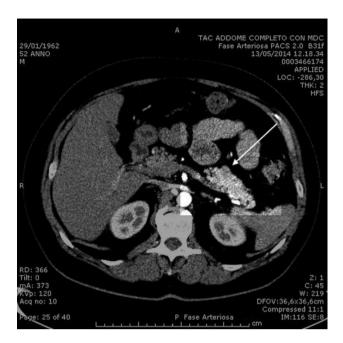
Arterial phase of computed tomography (CT) scan. The arrow shows a hypodense mass in the pancreatic body.
